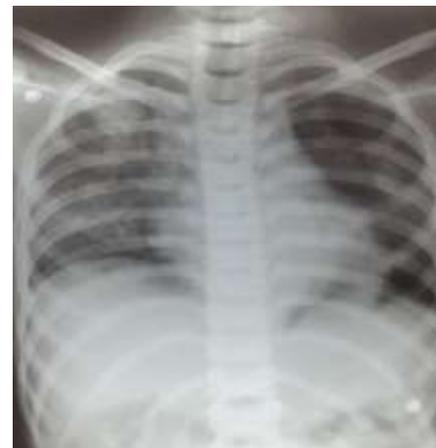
Chest Radiograph: Significant resolution of parenchymal opacities
